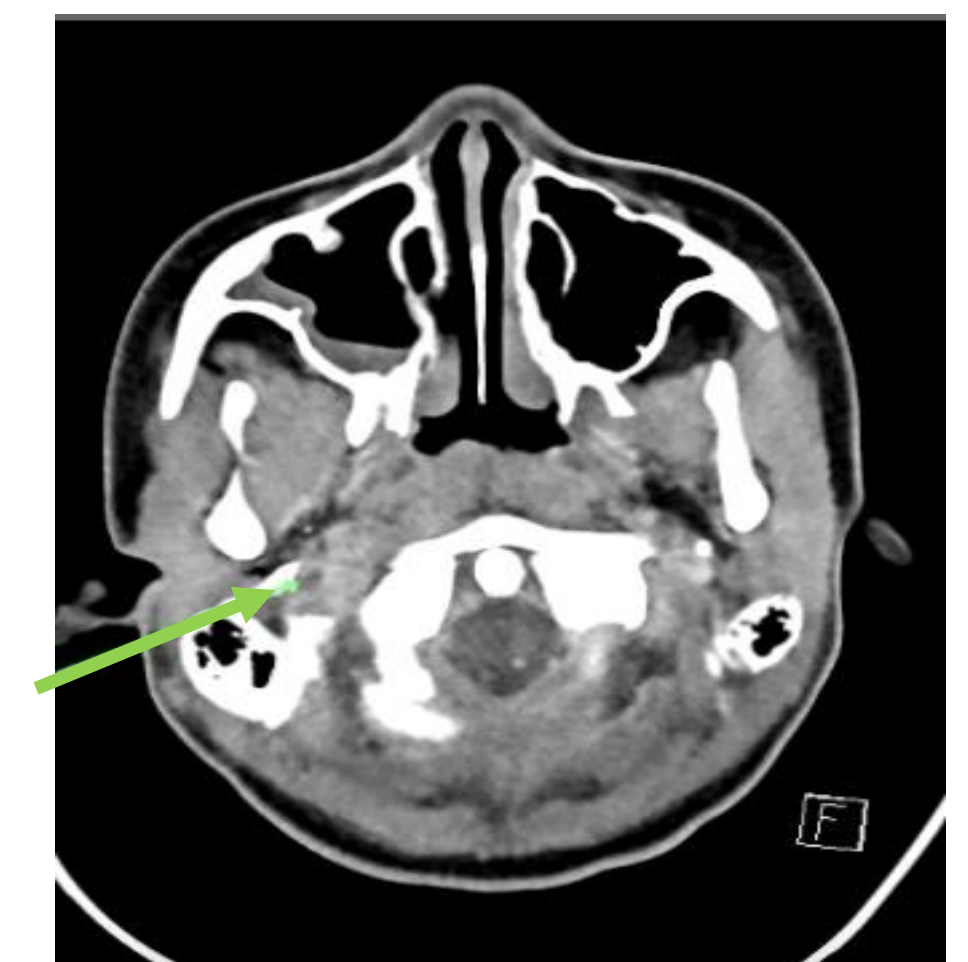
CT Neck with Contrast, axial cut, bilateral, right greater than left, nonocclusive thrombi of the internal jugular veins (arrow)
